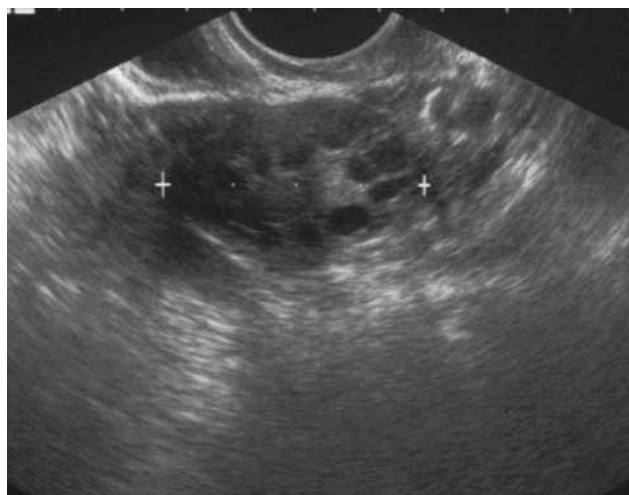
Torsion of right enlarged polycystic ovary in a 22-year-old woman with a 6-hour history of lower abdominal pain. a) Axial abdominal MRI (T2-weighted) shows bilateral adnexal enlargement with torsed and thickened right peduncle (arrowhead). b) Ultrasonography revealed PCOS findings, but not tube torsion.
